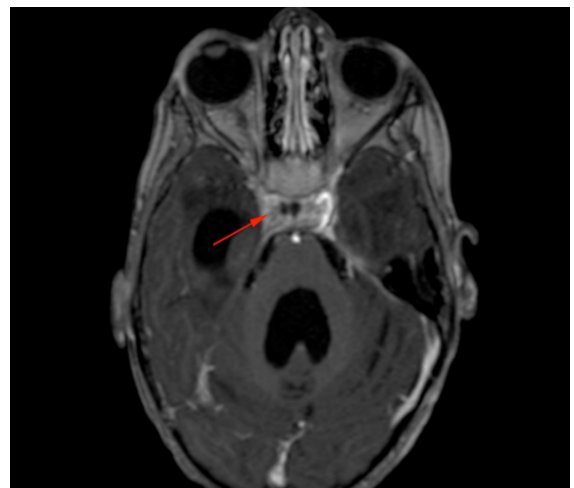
Brain MRI on D42 of anticoagulant treatment. Absence of thrombosis of the right cavernous sinus reflected by 1 normal enhancement. Significant quadriventricular hydrocephalus (sequelae of meningitis)
